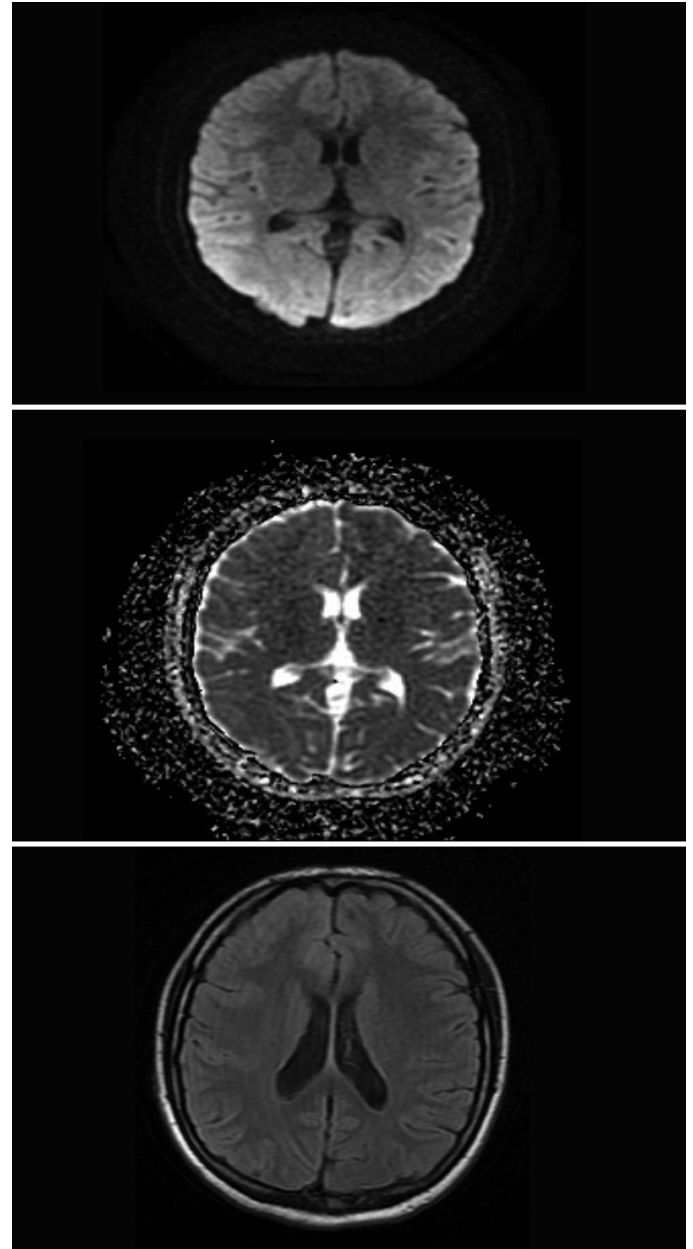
In the control diffusion MRI and cranial MRI examination after 1 month, the diffusion restriction, hyperintense signal changes, increased thickness of the gyri, mild flattening of the accompanying sulcal structures, slight flattening of the right lateral ventricular contour, and slight shift of the midline structures detected in the previous examination show total regression
